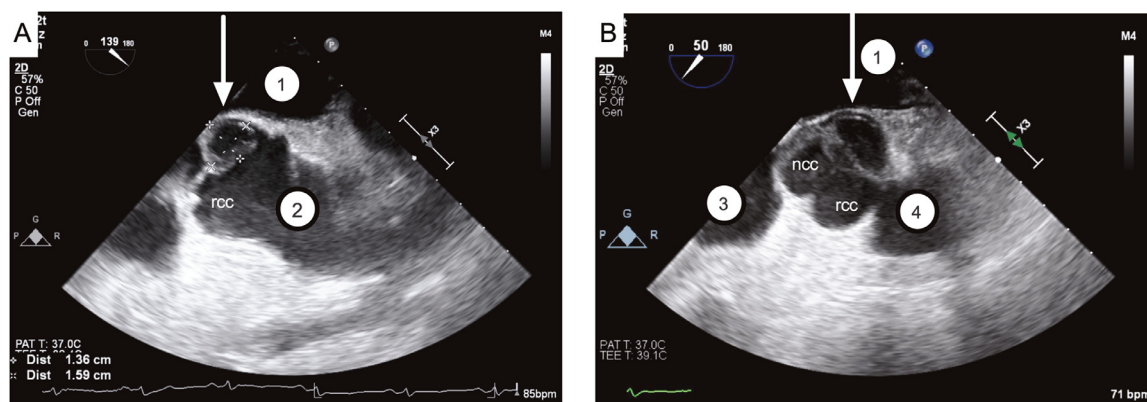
On the third day postimplant of the left ventricular assist device, a thrombus (white arrows) in the left coronary cusp of the aortic valve was observed on transesophageal echocardiography in the mid-esophageal aortic valve (A) long-axis and (B) short-axis views. Also highlighted are the left atrium (1), ascending aorta (2), right atrium (3), right ventricular outflow tract (4), right coronary cusp (rcc) and noncoronary cusp (ncc).
